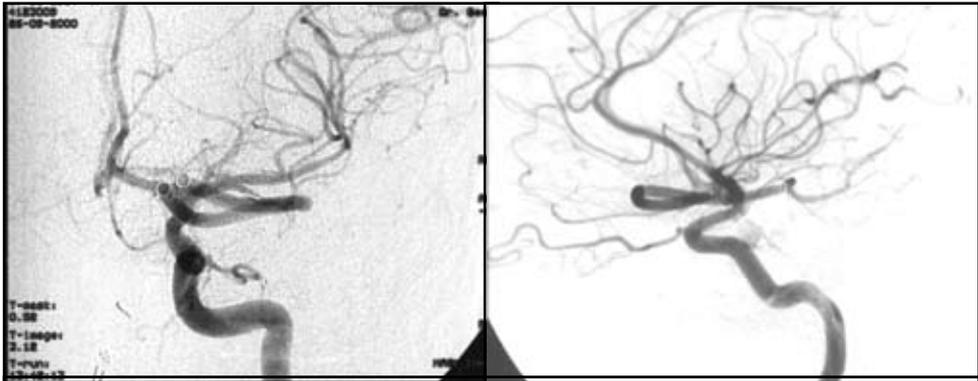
AP (upper left) and lateral (upper right) angiograms of the patent, reconstructed PComA bypass. A computer generated 3D reconstruction of the bypass was made (left). The original two-dimensional angiograms were used as a template. We thought that an artist's 3D reconstruction of these vessels would be more useful than a 3D digital subtraction angiogram, a magnetic resonance angiogram, or a computed tomographic angiogram, because it would allow us to emphasize the PComA bypass and show the BA and the P1 segment of the PCA. In the anterior angiograms, the BA and the P1 segment did not fill, of course, so the images of these arteries were computer
